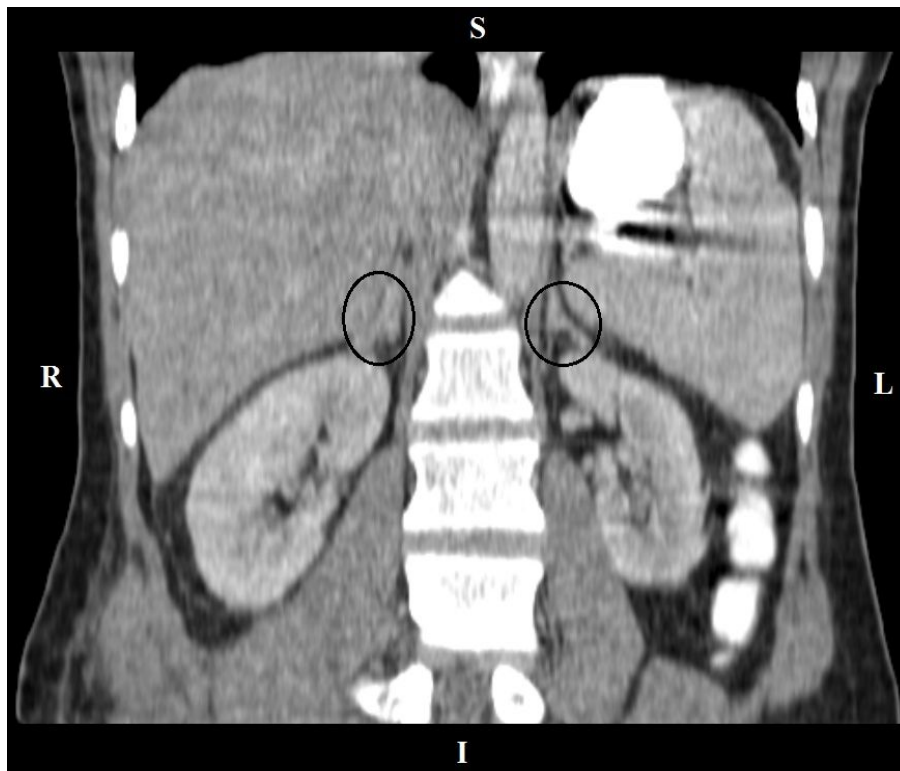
Axial CT image for Male (50 years) shows typical location of both right adrenal gland (linear shape) and left adrenal gland (triangular shape).
